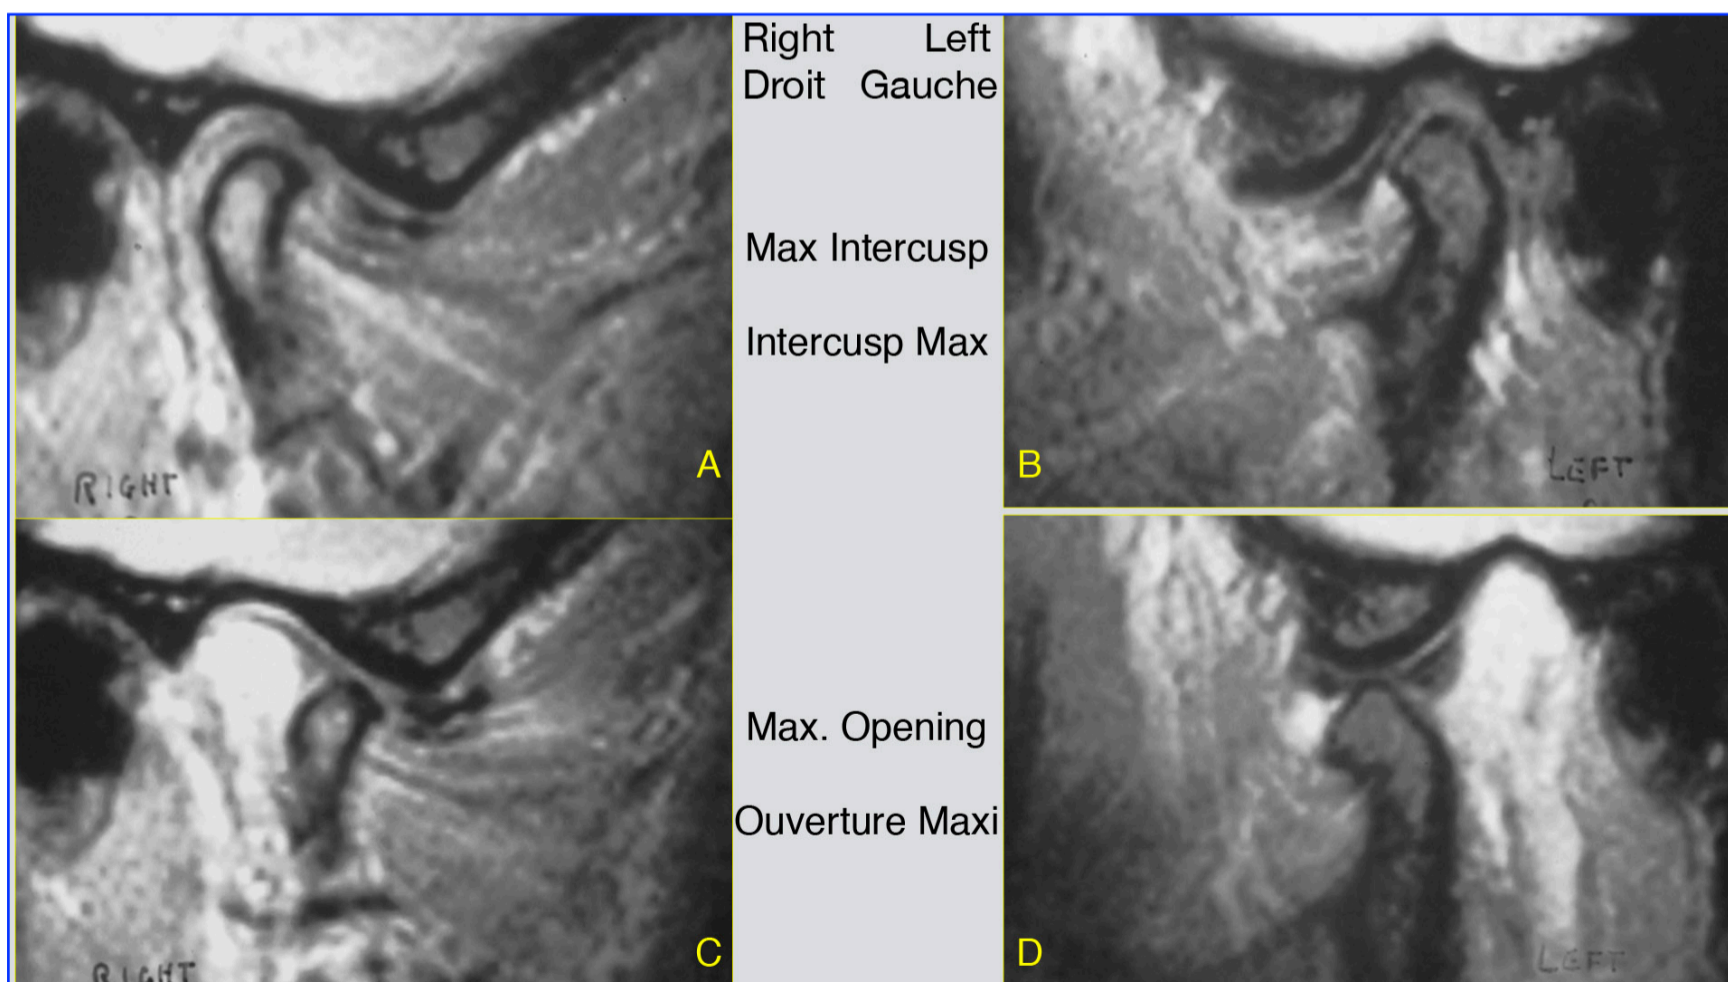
Patient seen in emergency for an irreducible anterior dislocation of the right joint disc, with an MRI and a surgical appointment for menisectomy at 15 days.
